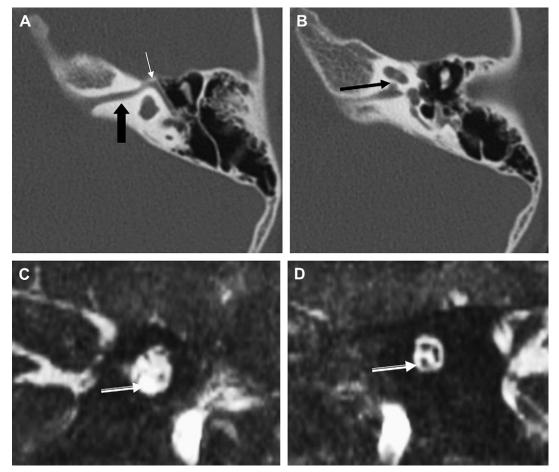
Hypoplastic internal auditory canal (IAC), occluded cochlear neural foramen. (*A*, *B*) Axial CT images of the left ear reveal an extremely narrow internal auditory canal (*thick black arrow*) contiguous with the anterior genu of the facial nerve canal (*white arrow*) with a bony plate occluding the cochlear neural foramen (*long black arrow*). (*C*) Sagittal T2WI of the left ear reveals a vacant anteroinferior fundal IAC quadrant (*white arrow*) indicating that the cochlear nerve is absent. (*D*) Sagittal T2WI of the right ear reveals a normal cochlear nerve (*white arrow*). (*Courtesy of* C.D. Phillips, MD, Charlottesville, VA.)
